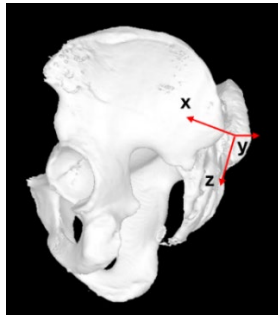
Pelvic instrumentation. Images from instrumentation CT.
